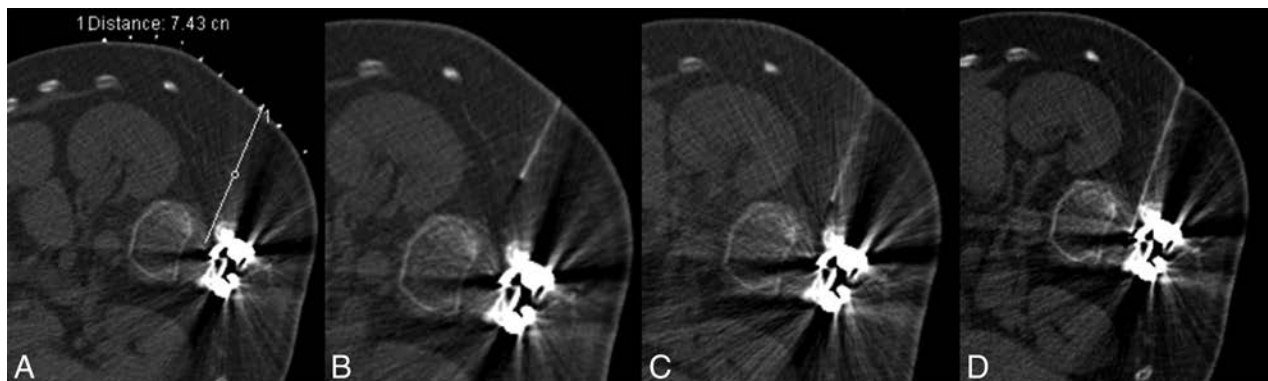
A 32-year-old man with SMA2 (case 5). *A*, Planning scout CT image with grid placement, obtained in the lateral decubitus position. *B*, Initial CT fluoroscopy image shows the needle more anteriorly oriented than desired. *C*, With basic needle manipulations, the needle is directed more posteriorly. *D*, Technically successful TFLP with the needle positioned immediately anterior to the facet.
